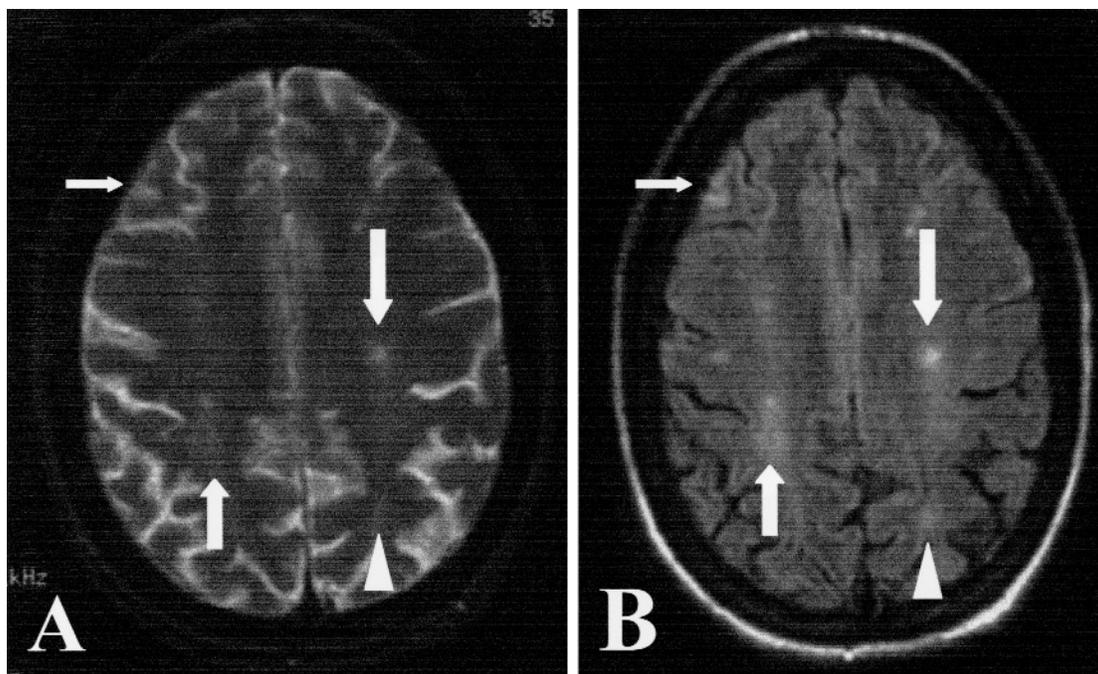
FLAIR and T2 in neuropsychiatric SLE. A. An axial slice showing CSF and cortical, subcortical, and deep white matter lesions by conventional T2 (TE 100 ms, TR 3000 ms). B. The same slice by FLAIR (TR 10000 ms, TE 145 ms, TI 2200 ms). Comparing A with B, the signal from CSF is markedly attenuated (darker) with FLAIR, and the lesions (areas of increased signal) have greater conspicuity on FLAIR relative to the T2 image. The focal and diffuse, ill-defined lesions (medium size arrow on both figures) are more visible on FLAIR (B) compared to T2 (A). Although the larger focal white matter lesion (large arrow on both images, representing a small infarct) is visible in the T2 image (A), the conspicuity is far better on the FLAIR image (B). Similarly, the ill-defined white matter lesions in the distal lobes (arrowhead) are barely visible on the T2 weighted image (A), but are much more obvious on the FLAIR image (B). Finally, the cortical/subcortical lesion (a reversible lesion typical of lupus acute leukoencephalopathy) in the frontal lobe (smallest arrow in both figures) is not apparent at all by T2 (A), but is obvious by FLAIR (B).
